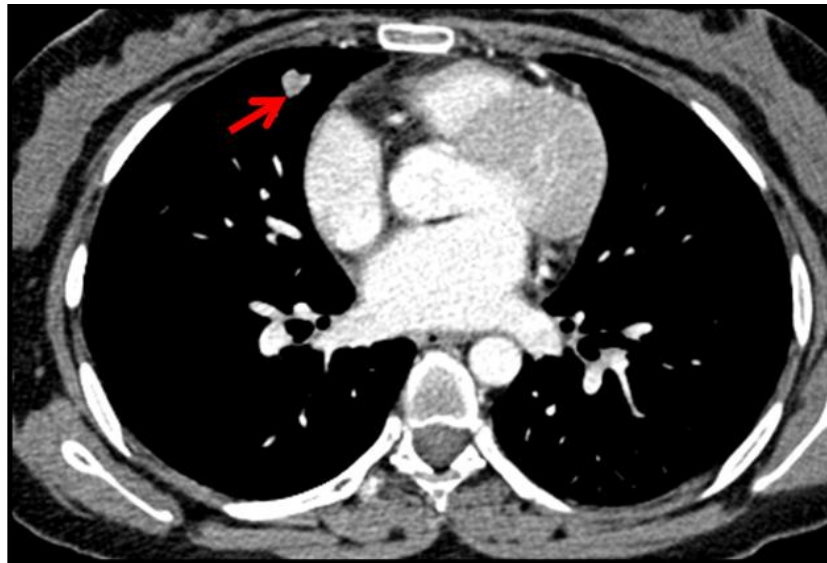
Patient 4: CT chest: Right nodular lesion corresponding to octreotide scanning
